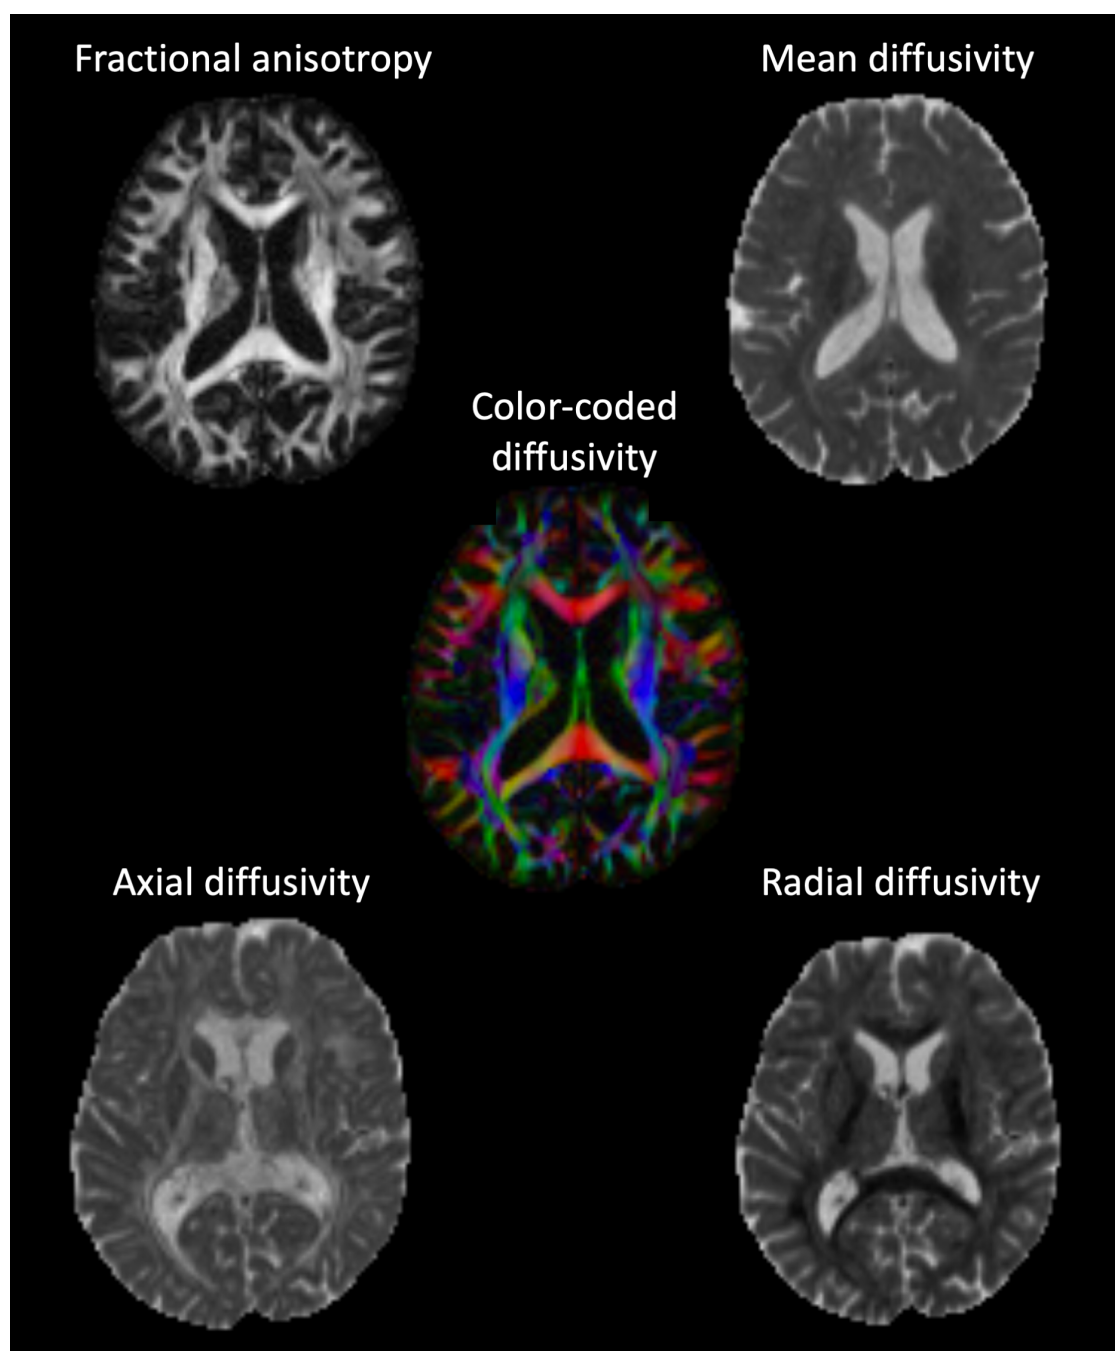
Scalar maps obtained with fitting the diffusion tensor from a set of DWI data.
